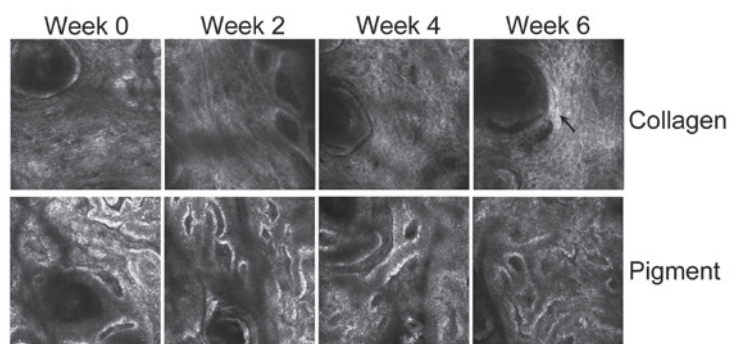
PRP treatments improve human skin conditions. Skin computed tomography examination (magnification, x200) of collagen (upper panel) and pigment (lower panel) around the injection sites before PRP treatment (week 0) and after PRP treatment (at 2, 4 and 6 weeks). Black arrow in the upper panel at week 6 indicates the collagen fibers. PRP, platelet-rich plasma.
